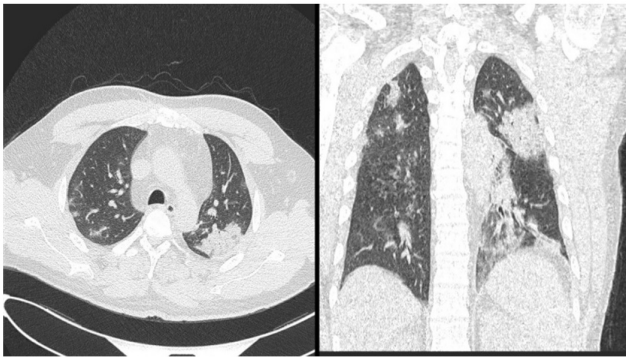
Chest CT-scan showing bilateral peripheral rounded and patch like multifocal ground-glass opacities with areas of consolidation noted mostly in the left lung. CT severity: Moderate to severe COVID-19 pneumonia.
